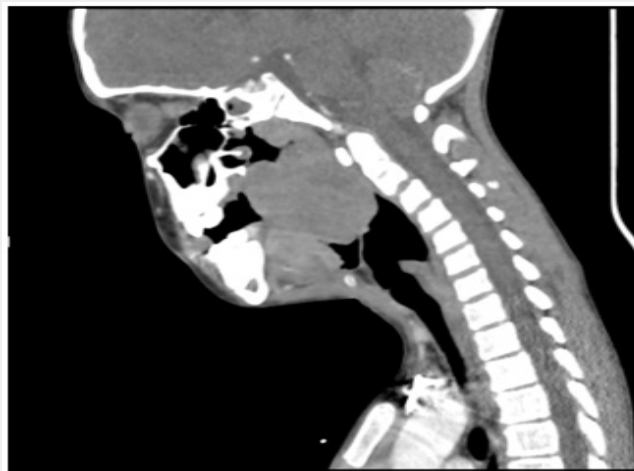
Sagittal view of head and neck CT scan. A 6.5 x 5.7 x 6.4 cm solid mass occupying the left palatine tonsil area.
